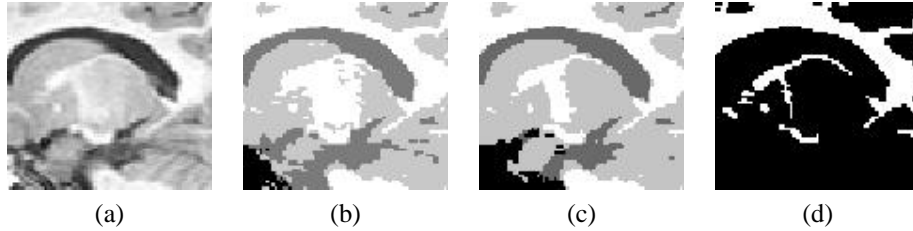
Misclassification in thalamus: Substantial amount of deep grey matter classified as white. (a) MR image of a 2-year-old brain (b) EM segmentation using the adult atlas (c) EM segmentation using the 2-year-old child atlas (d) manual segmentation
